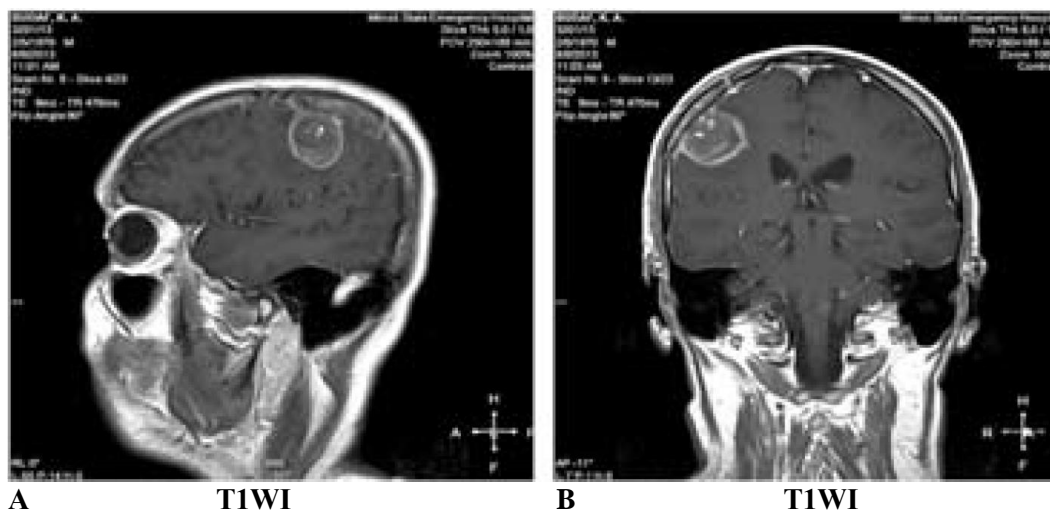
MRI of patient B., 43 years old. Diagnosis: glioblastoma of the parietal lobe on the right. Postoperative cyst with a fluid component. A – T1WI, sagittal projection mode. B – T1WI, frontal projection mode 3 months after the surgery
